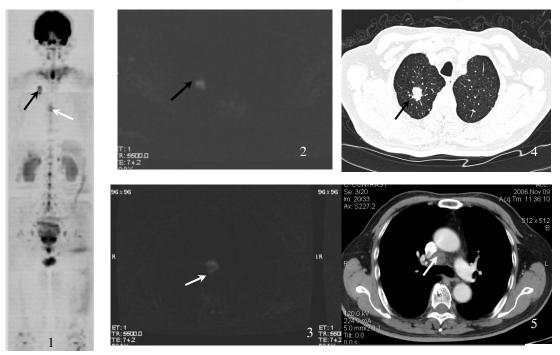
high signal intensities in right lung(black arrow) field and anterior of thoracic vertebra(white arrow) on reconstructed MIP image of STIR-DWI in a patient with normal prostate and elevated CEA, Fig2 showed high signal intensity in right lung field, Fig3 demonstrated an enlarged lymph node in mediastinum in axial STIR-DWI image, Fig4 and 5 showed right lung tumor and swelling lymph node respectively
